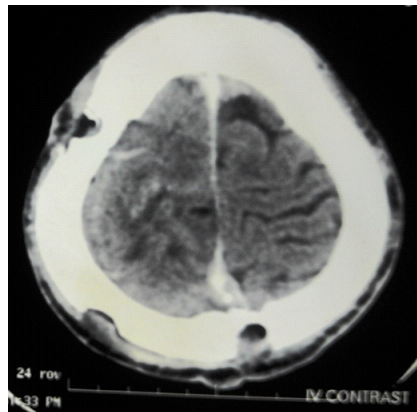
Post operative CT contrast Axial image of parasagittal meningioma
